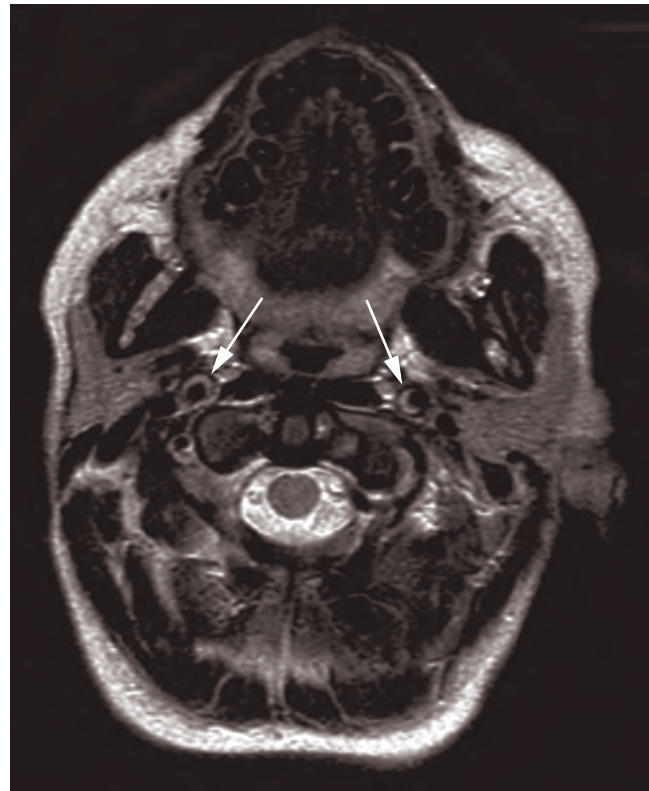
Bilateral internal carotid artery (ICA) dissection. Flow voids indicate patency of each arterial lumen; the crescent-shaped hyperintensity is the intramural thrombus on each side. (MRI T2W.)
